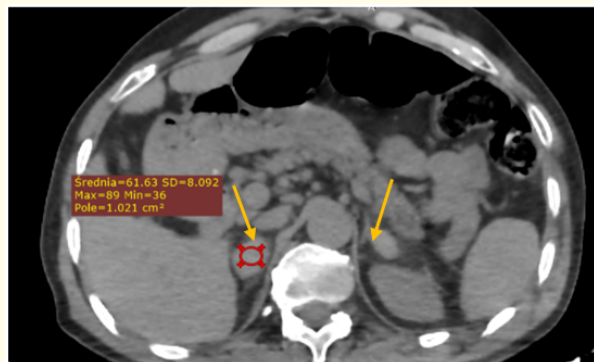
Axial slices of an abdominal CT scan without contrast injection showing two adrenal hematomas.
